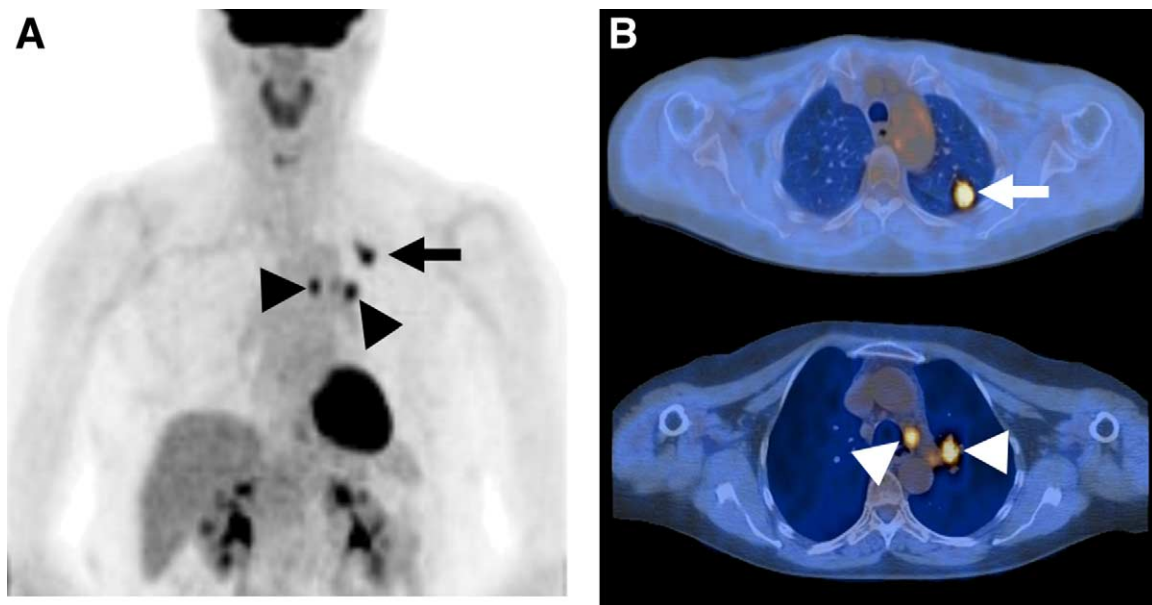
Nodal staging with FDG-PET. A 59-year-old subject with biopsy-proven NSCLC in the left upper lobe. (A) Frontal MIP image from an FDG-PET scan showing intense uptake in the left lung cancer (arrow), as well as in left hilar and left mediastinal lymph nodes (arrowheads). (B) PET/CT fusion images confirming uptake in the left upper lobe cancer (arrow), with a maximum SUV of 8.3. Coregistration with CT images demonstrate that the nodal disease is located in the left hilum and in the left paratracheal space (arrowheads). This information can be useful in planning confirmatory biopsy procedures such as mediastinoscopy or transbronchial needle aspiration.
